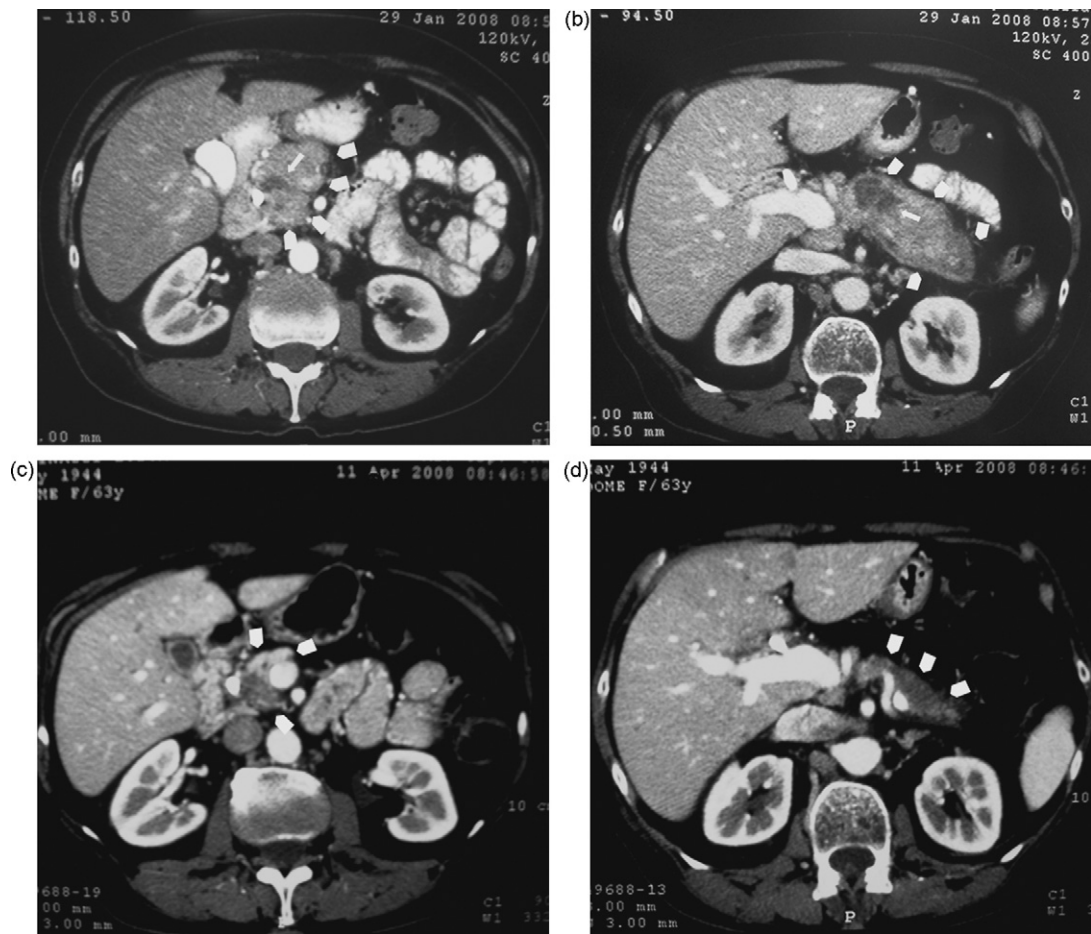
A contrast-enhanced axial CT scan (a and b) shows that the pancreatic gland (arrowheads) is swollen with some hypodense areas (arrows). The CT check (c and d) after 6 weeks of steroid treatment shows the marked decrease in size of the gland, either head or body and tail (arrowheads).
